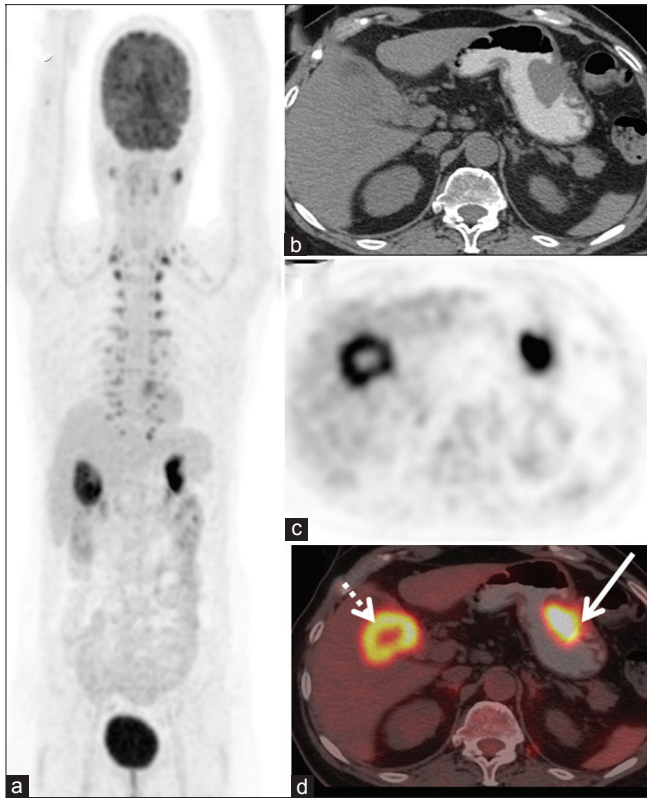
(a) Maximum intensity projection image showing two focus-increased fluorodeoxyglucose uptake in the abdomen (b) Axial computed tomography image showing circumferential wall thickening in the gall bladder and polypoidal lesion in the body of the stomach along the greater curvature which shows increased fluorodeoxyglucose uptake on positron emission tomography (c) and fused axial positron emission tomography-computed tomography image (d)
